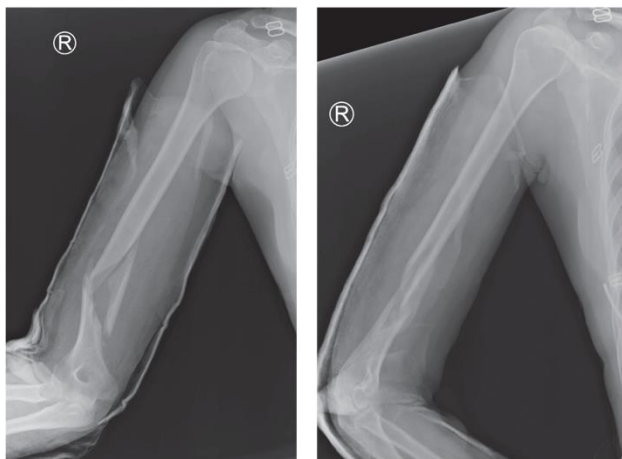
X-ray images of patient B., front and lateral views
